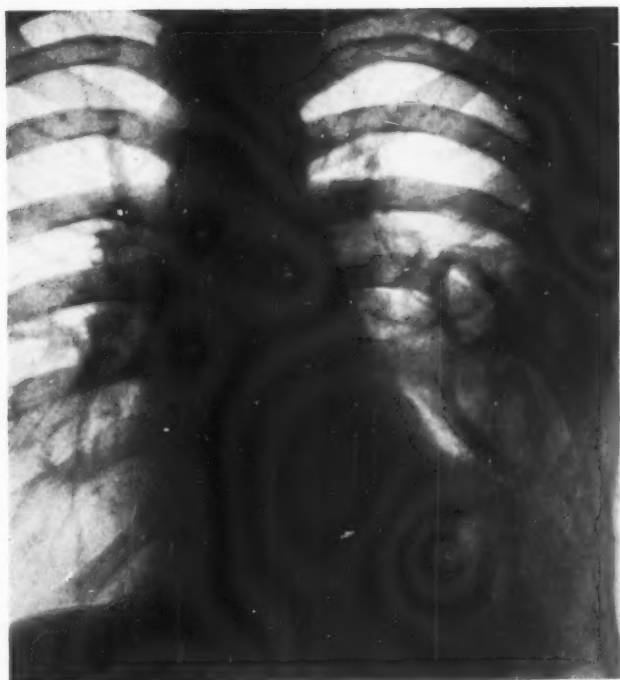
X-RAY SHOWING REGENERATION OF TWO RIBS RESECTED FOR DRAINAGE OF A CHRONIC EMPYEMA.
